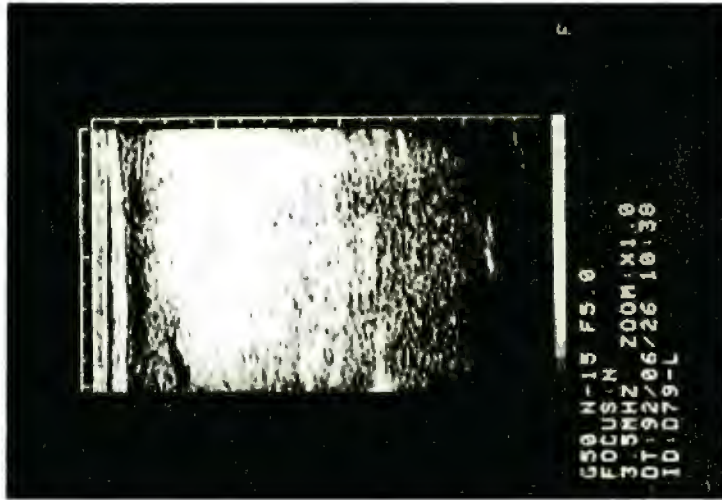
Ultrasonogram of hepatic dystrophy.
